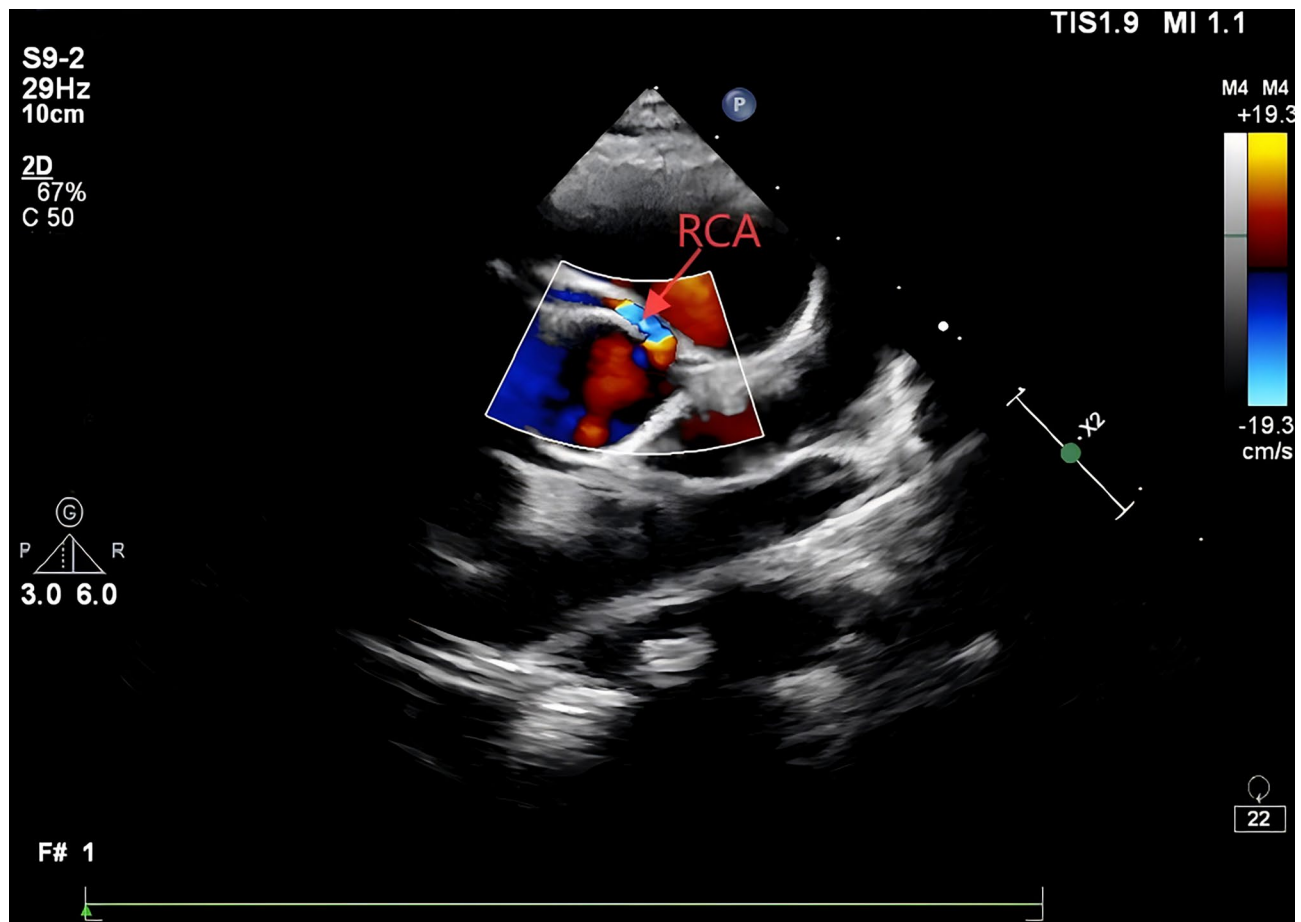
The white box indicates the sampling location for color Doppler imaging. Color Doppler images show the right coronary artery originating from the left coronary sinus of the aorta, along with accelerated blood flow within the intramural segment
